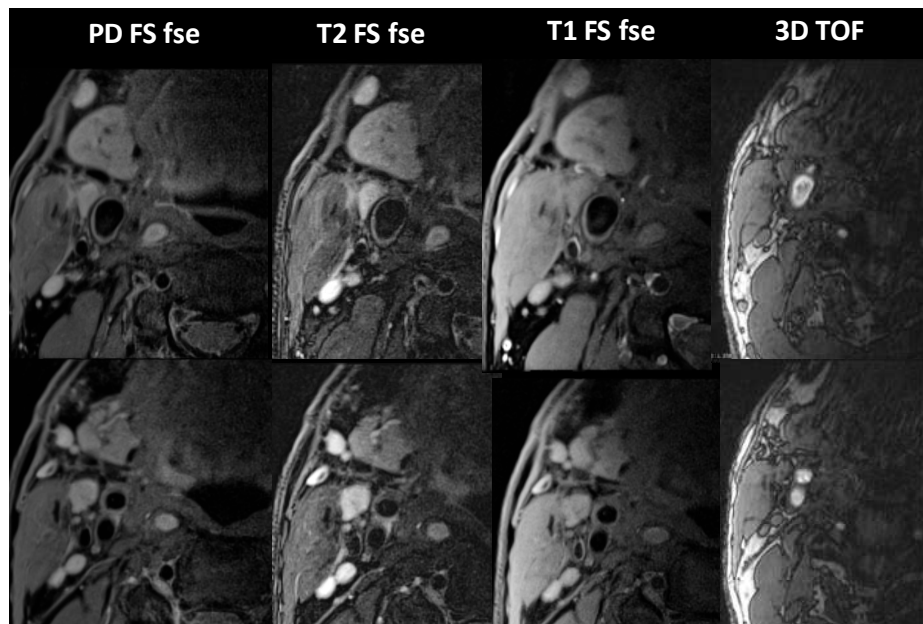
MRI plaque imaging performed on a normal volunteer.
